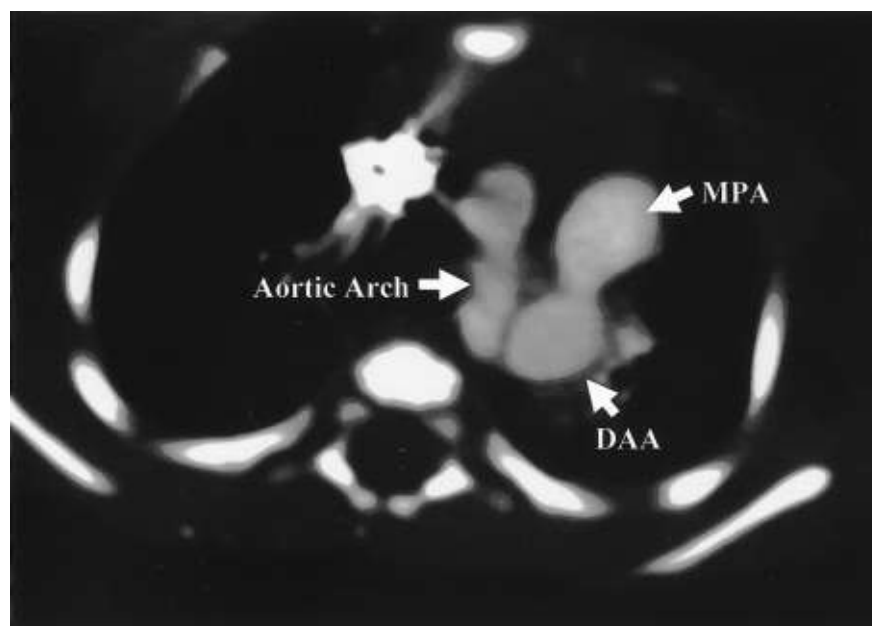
On cystographic computed tomography the aortic arch was to the left of the trachea, and a vessel with a localized dilatation (DAA) was existed in leftward of the aortic arch. MPA, main pulmonary artery; DAA, ductus arteriosus aneurysm.
